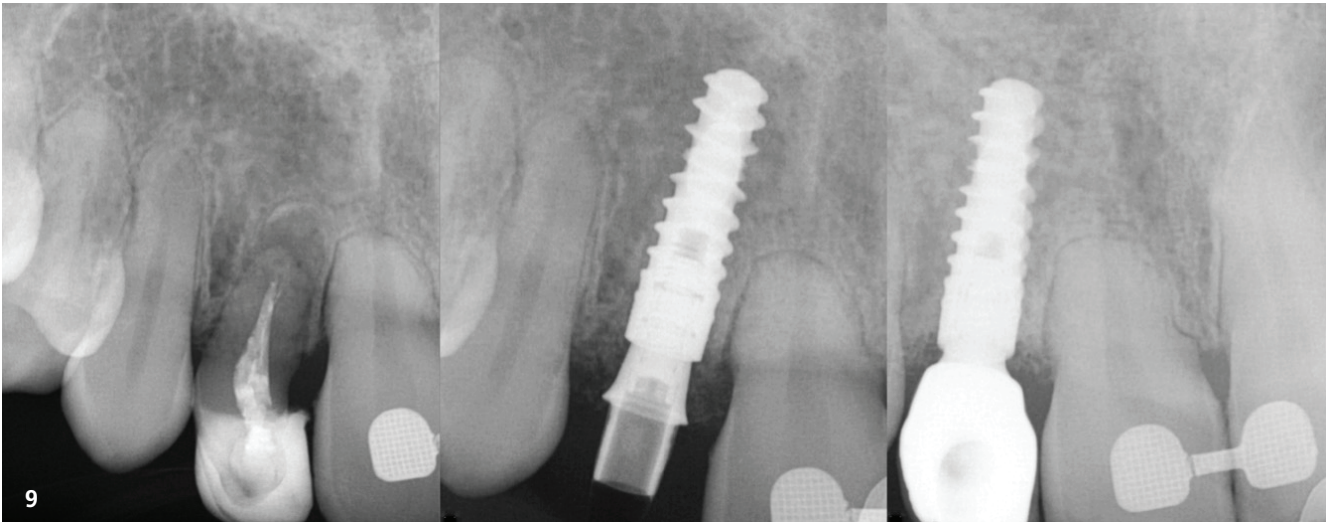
Radiographs taken at different stages.
